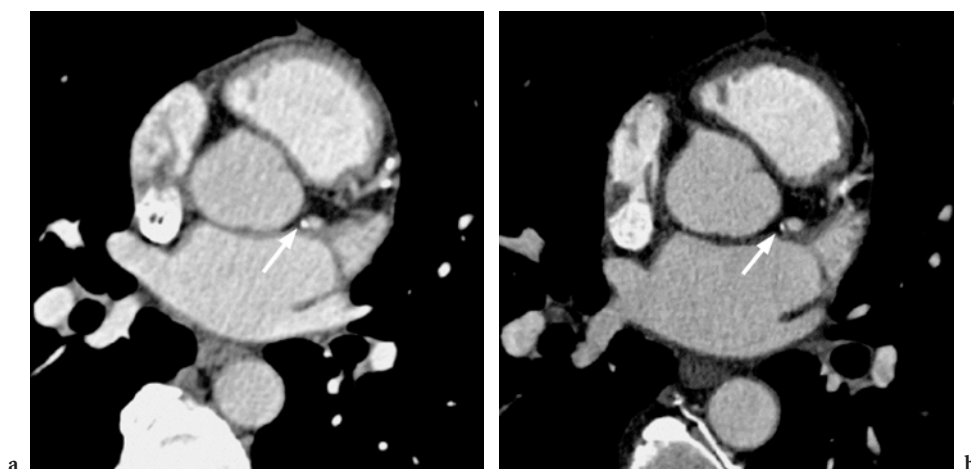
Comparison between investigations with a 4-slice CT and b 64-slice CT. In addition to the fact the scan was acquired within 10 instead of 40 s with the 64-slice CT, the images reveal a higher spatial resolution and less blooming of calcium (*arrow*) in the coronary arteries
